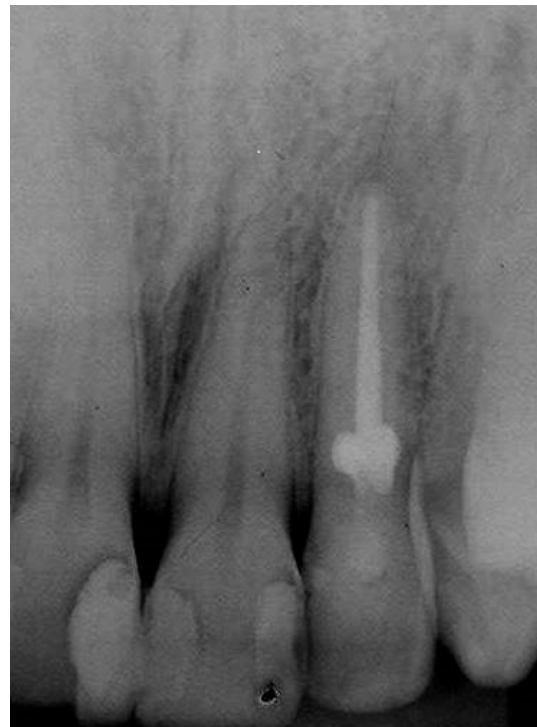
3-month following-up radiograph
